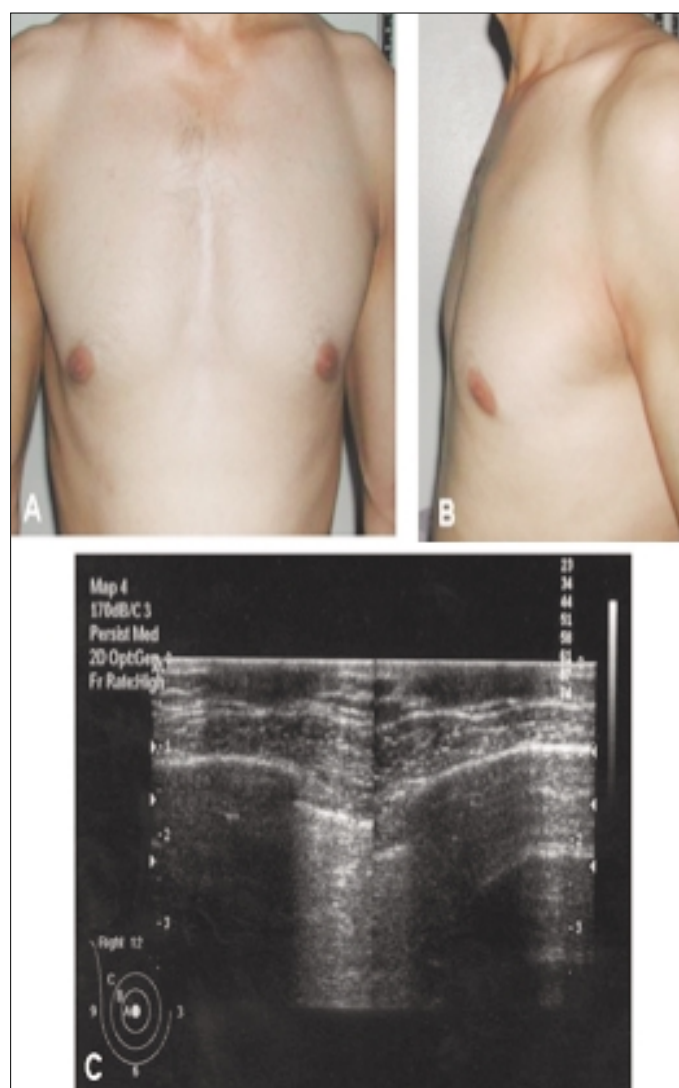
Recovery of gynaecomastia after achieving euthyroidism with radioiodine (a and b: on the physical examination; c: by ultrasound)
